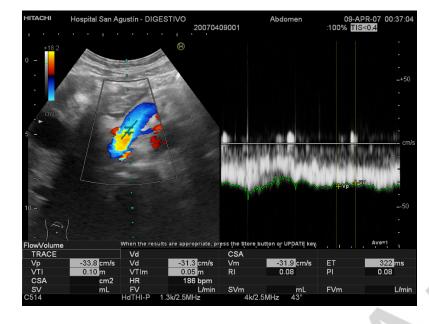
Doppler ultrasound exam performed one month after cavity drainage and sclerosis with absolute alcohol. A 3 cm heteroechogenic area with poorly defined contours that corresponds to the drained residual cavity can be seen. The splenoportal axis has a regular, normal caliber.
